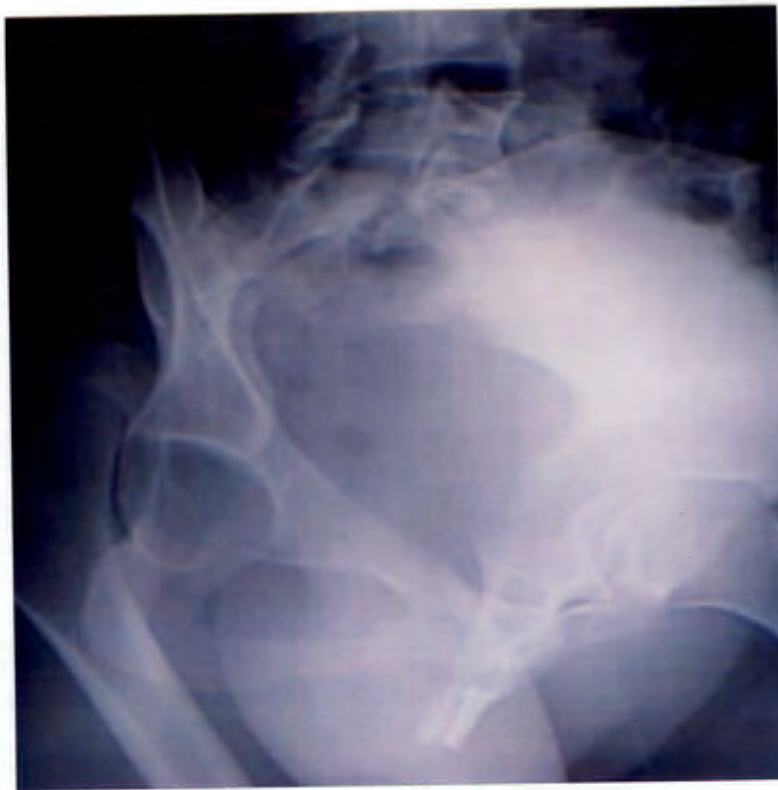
The majority of our cases are taken with the x-ray beam been tilted 45°. The view is somewhat distorted showing oval obturator foramen but demonstrates the uninterrupted view of the posterior wall. In Fig.16 the OOD-view with the patient tilted demonstrates the normal shaped obturator foramen. Unfortunately despite the effort of tilting the patient the quality of this particular radiograph is poor.
